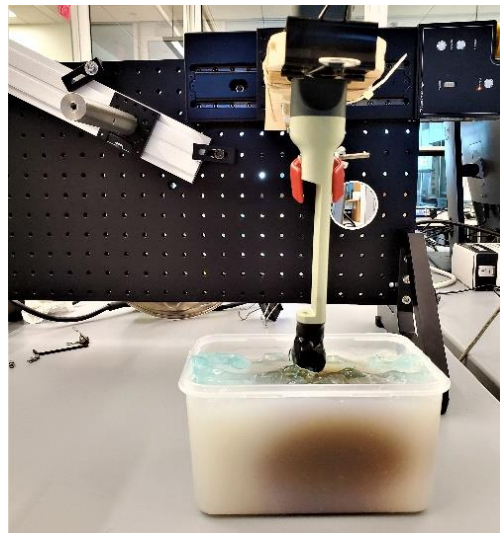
Three-dimensional ultrasound setup using linear actuator and ultrasound probe.
